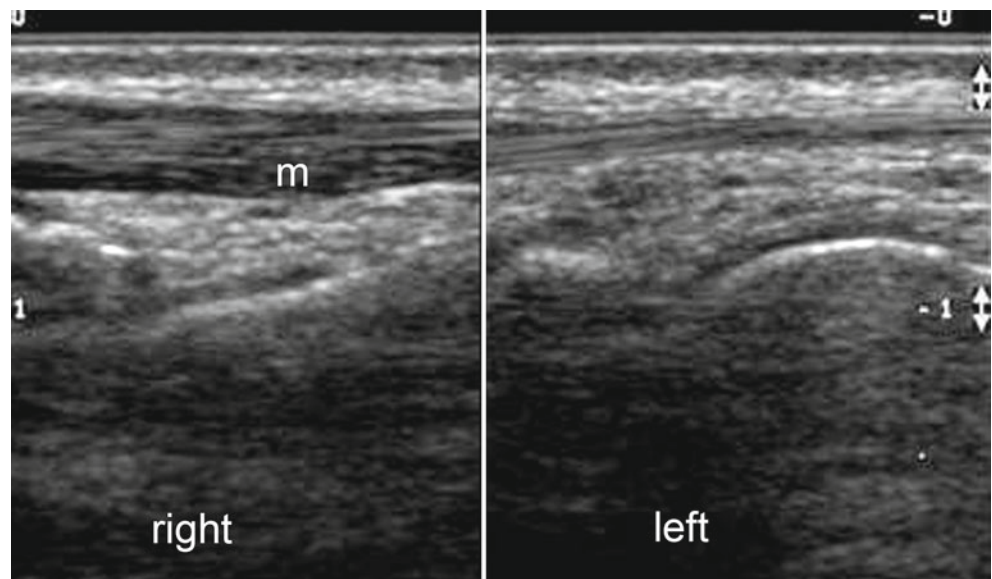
Accessory extensor indicis muscle. Grey scale ultrasound image (comparative side-by-side longitudinal view in the dorsum of the hand) shows a hypoechoic structure (*m*) attached to the extensor indicis tendon in the right side. The left side is unremarkable
